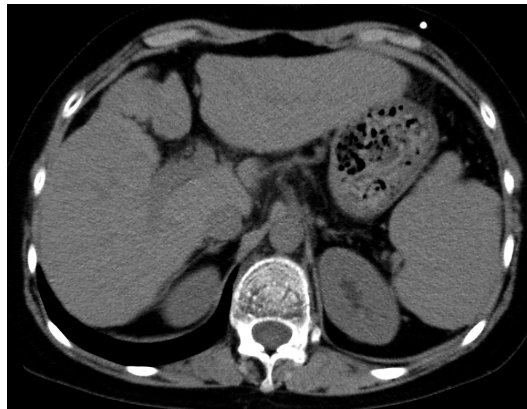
Abdominal simple computed tomography showing dullness of the marginal liver, swelling of the left lobe, and splenomegaly.
